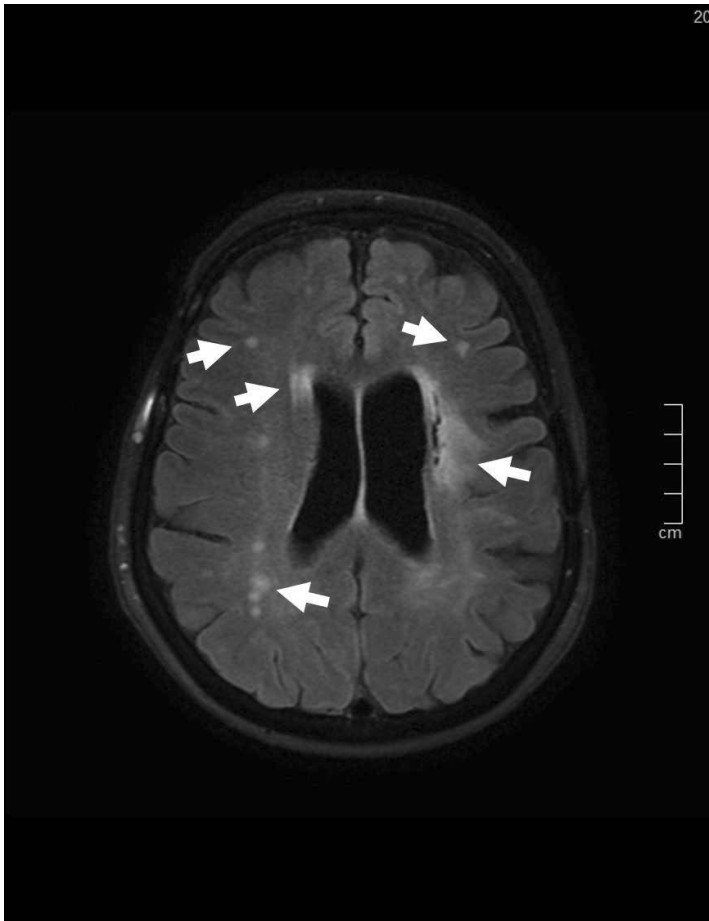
White matter lesions (some marked with arrow) in a brain MRI.
